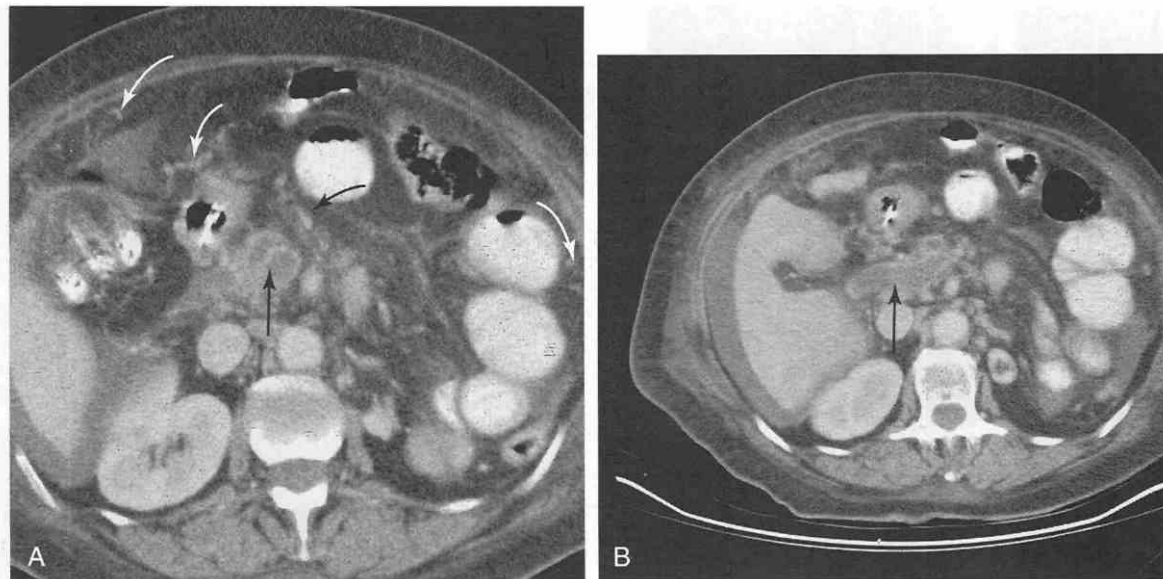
A*, CT scan taken at the level of the lower pancreas shows low-density filling defects in the superior mesenteric veins (arrow) to the right of the superior mesenteric artery. In such cases, the vein may be mistaken for a dilated common bile duct. Distinction can be made by following the anatomy on contiguous sections. Also, note the excessive number of venous collaterals in the peritoneal cavity (curved arrows). *B*, Scan taken at a higher level shows the large clot in the portal vein (arrow), extending toward the porta hepatis region.
